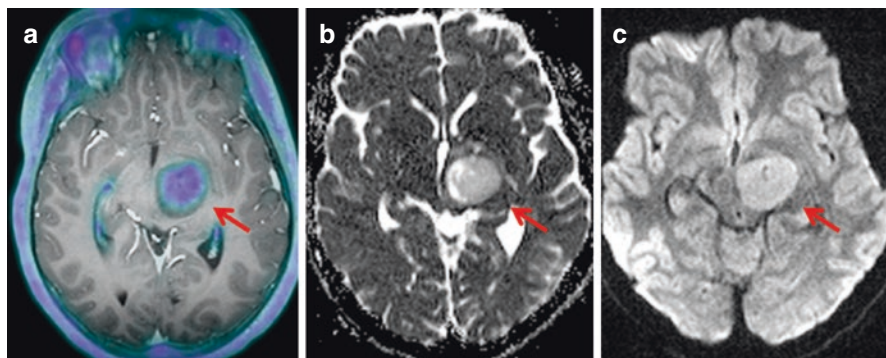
(a–c) Axial fused ^{18}F Choline PET/MR (a), ADC map (b) and DWI (c) show an ^{18}F Choline avid lesion in the left thalamus (a, arrow), with corresponding restricted diffusion on the diffusion-weighted images (b, c arrows).
